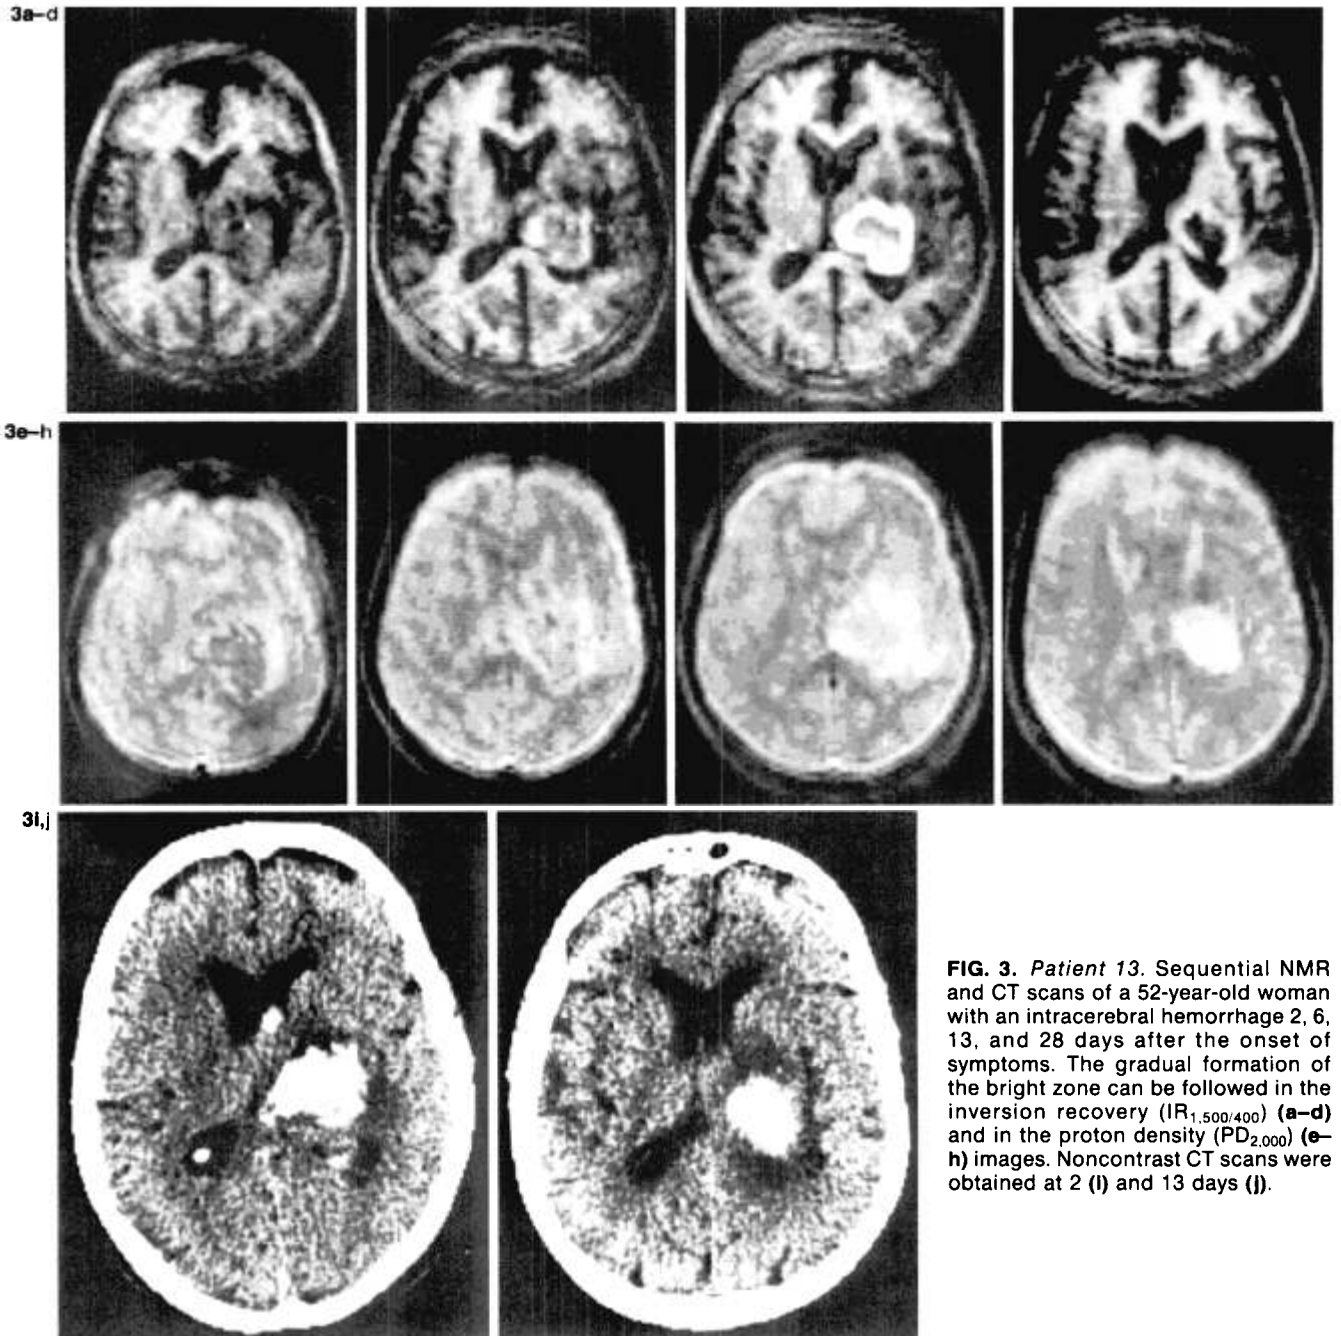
Patient 13. Sequential NMR and CT scans of a 52-year-old woman with an intracerebral hemorrhage 2, 6, 13, and 28 days after the onset of symptoms. The gradual formation of the bright zone can be followed in the inversion recovery ($IR_{1,500/400}$) (a-d) and in the proton density ($PD_{2,000}$) (e-h) images. Noncontrast CT scans were obtained at 2 (i) and 13 days (j).
